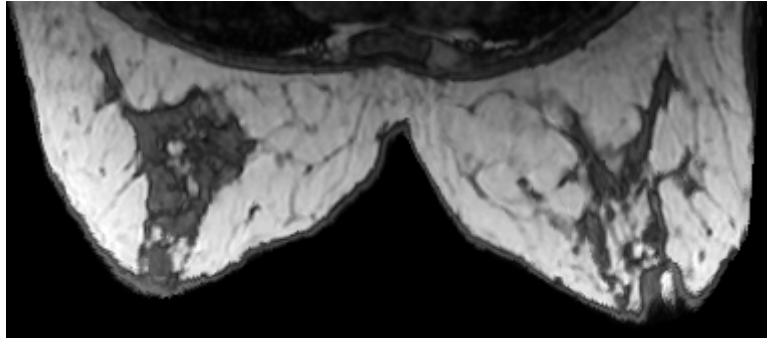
Example grayscale MRI image.
